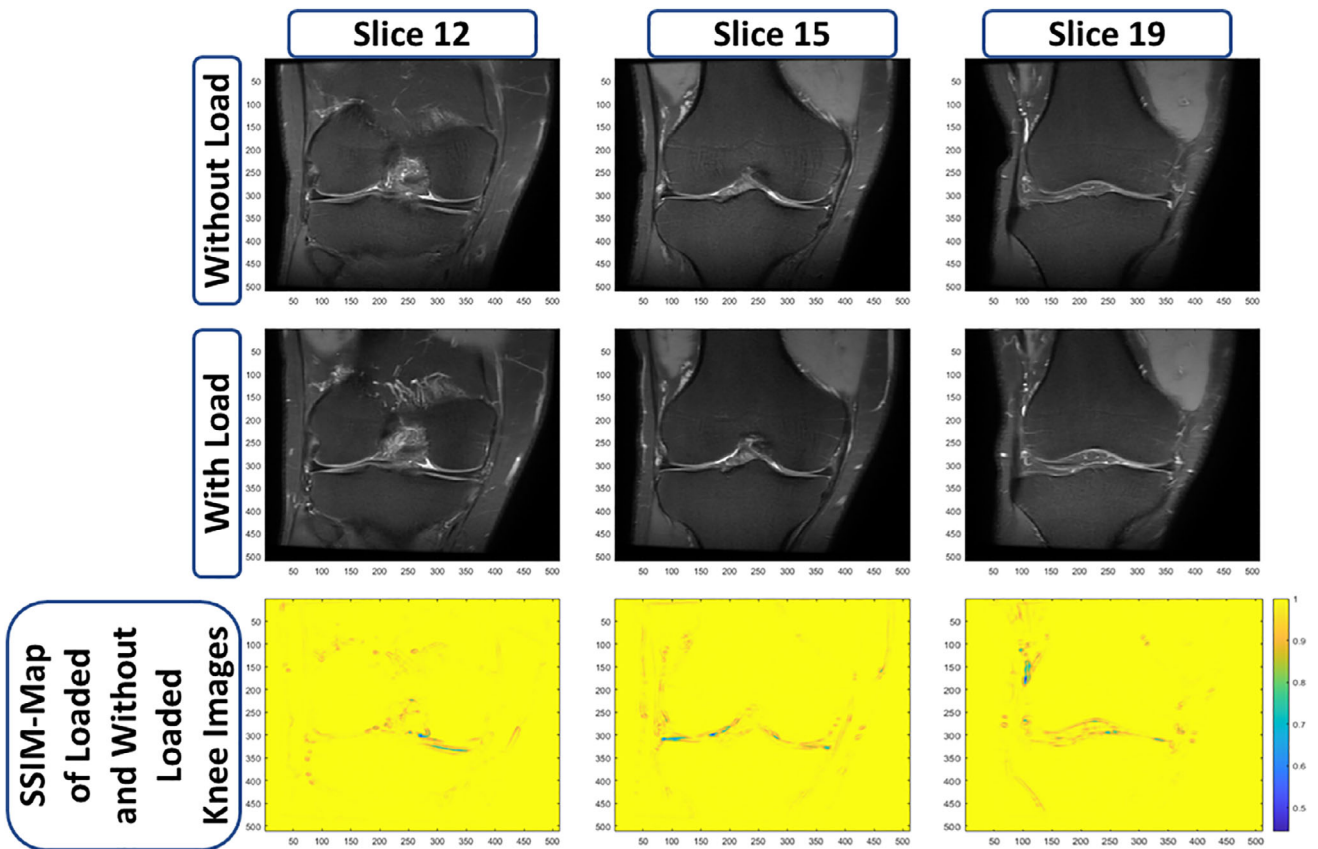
Similarity index mapping (SSIM) between MR images acquired using the loading device and without loading device for representative slices of the knee joint of a healthy subject.
